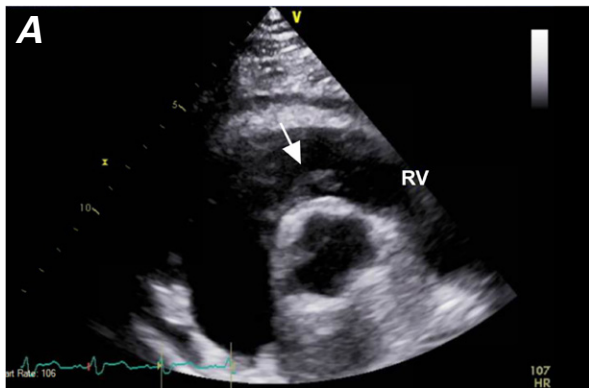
A) Transthoracic echocardiogram (parasternal short-axis view) shows a mass (arrow) in the right ventricle (RV). Transesophageal echocardiograms show B) a mass in the RV outflow tract (arrow) and, C) in 4-chamber view, a mass in the left ventricle below the mitral valve annulus (arrow).
